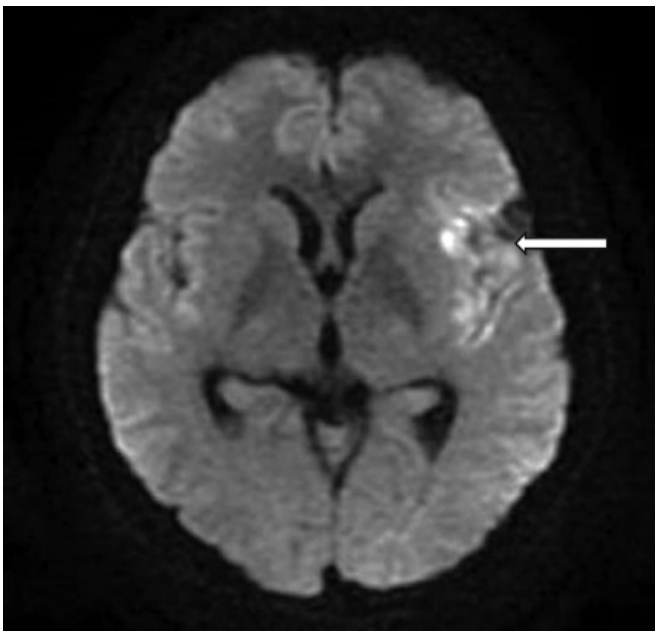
DWI sequence MRI brain: Left MCA infarction.
